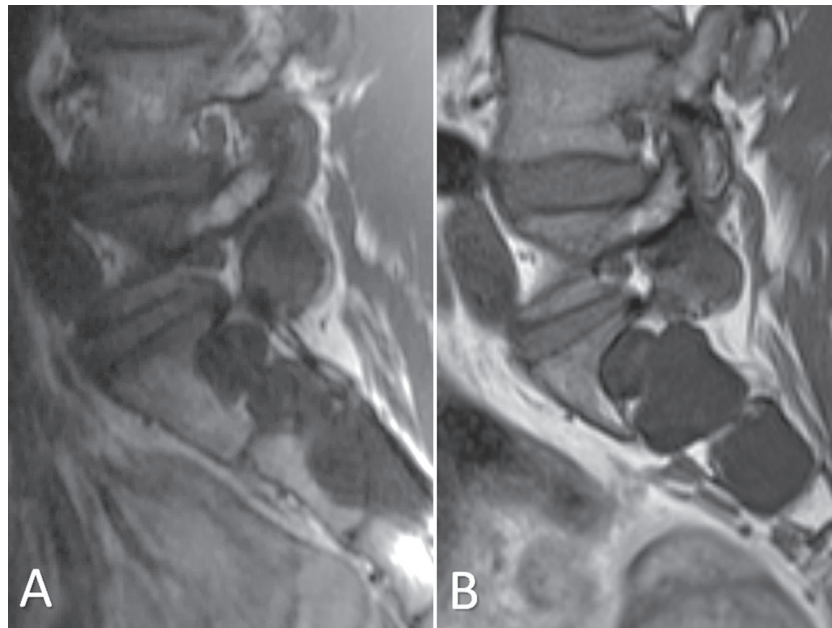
MRI of a male patient with MFS, 19 years old at baseline, who has developed an anterior sacral meningocele. (Left) sagittal T1 at baseline. Dural ectasia without anterior sacral meningocele. (Right) sagittal T1 at follow-up. Dura is crossing the anterior sacral cortex consistent with anterior sacral meningocele.
